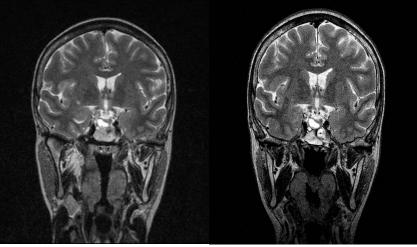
MRI of pituitary macroadenoma before (left) and after (right) two months of octreotid therapy.
